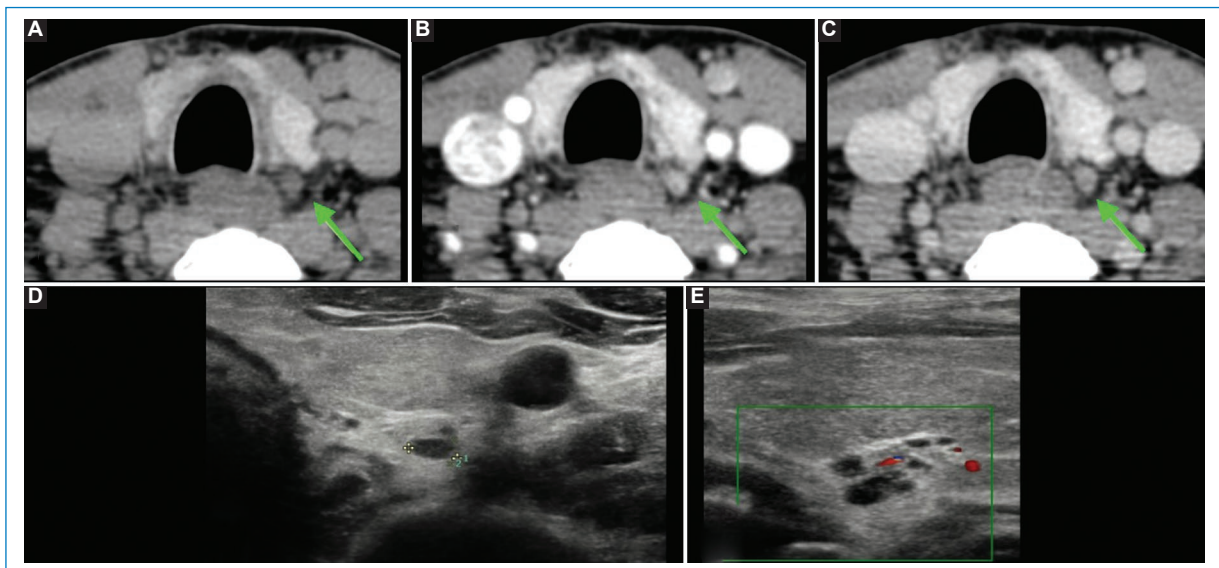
Complement to the 4D computed tomography (CT) and ultrasound (US) in the detection of parathyroid adenomas. CT in non-contrast (A), arterial (B), and venous (C) phases showing a left retrothyroid lesion suspicious for an adenoma (arrows), with its classic behavior in the dynamic study, highlighting its lesser spontaneous attenuation compared to the thyroid tissue. Correlation of the lesion on US on the transverse (D) and longitudinal (E) planes, with similar morphology, homogeneous and hypoechoic.
